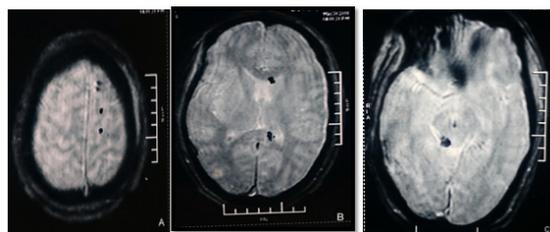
Magnetic resonance images show multiple small hemorrhagic foci on the hemispheric white matter (A), corpus callosum (B), and brain stem (C).
